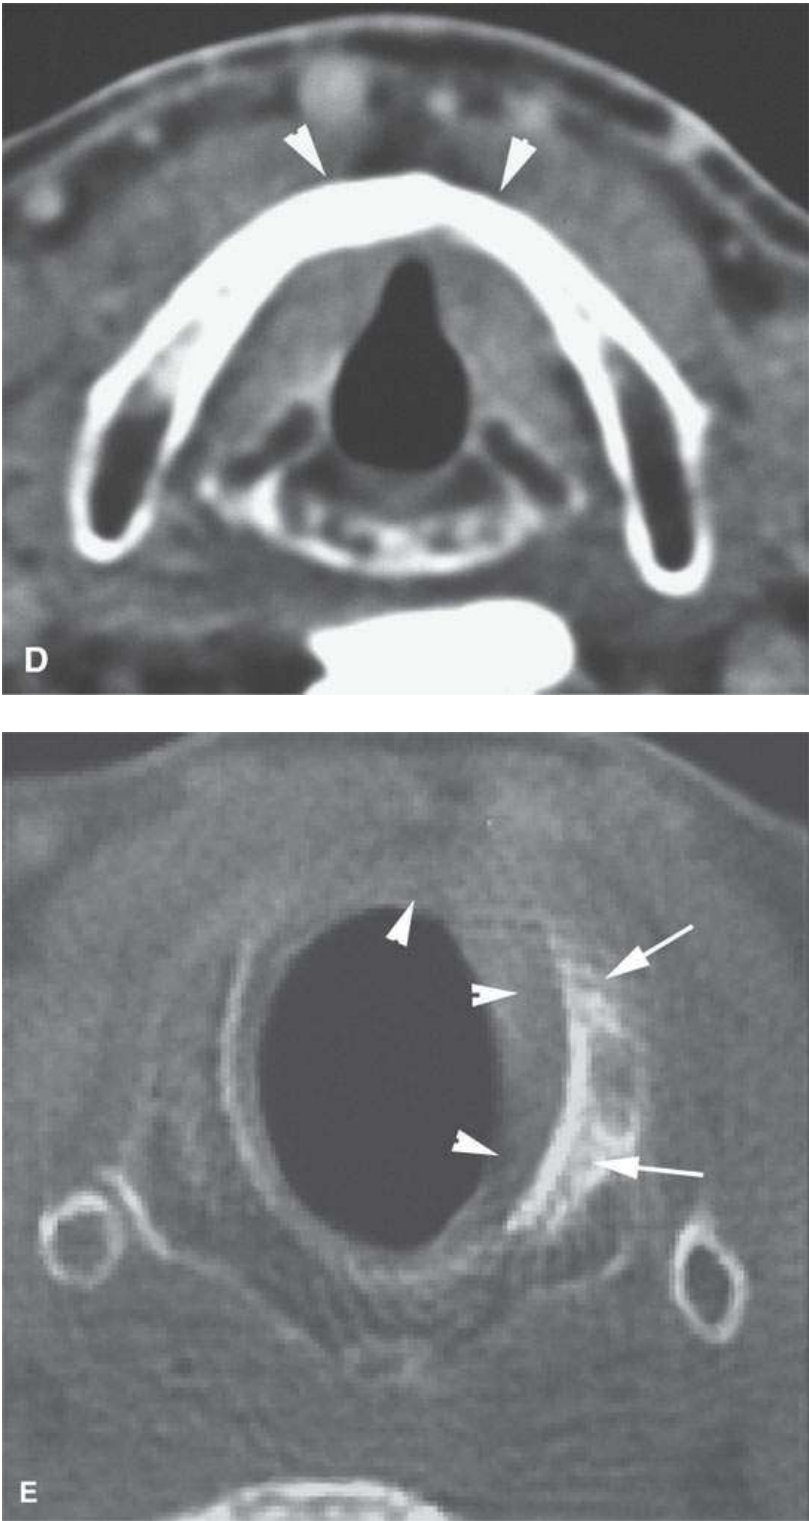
Two patients with laryngeal cancer. A, B: Pretreatment contrast-enhanced computed tomography (CECT) study showing cartilage erosion (between the *arrows*) due to adjacent cancer. Such gross cartilage erosion would usually suggest that the patient should be treated by total laryngectomy. C, D: CECT following radiotherapy showed the tumor to have responded completely and the cartilage to have remineralized (healed cartilage shown by *arrowheads*). E: CECT of another patient with subglottic spread (*arrowheads*) adjacent to the ossified cricoid cartilage. The cartilage sclerosis is reactive to adjacent tumor and a risk factor but not definitive evidence of cartilage invasion.
